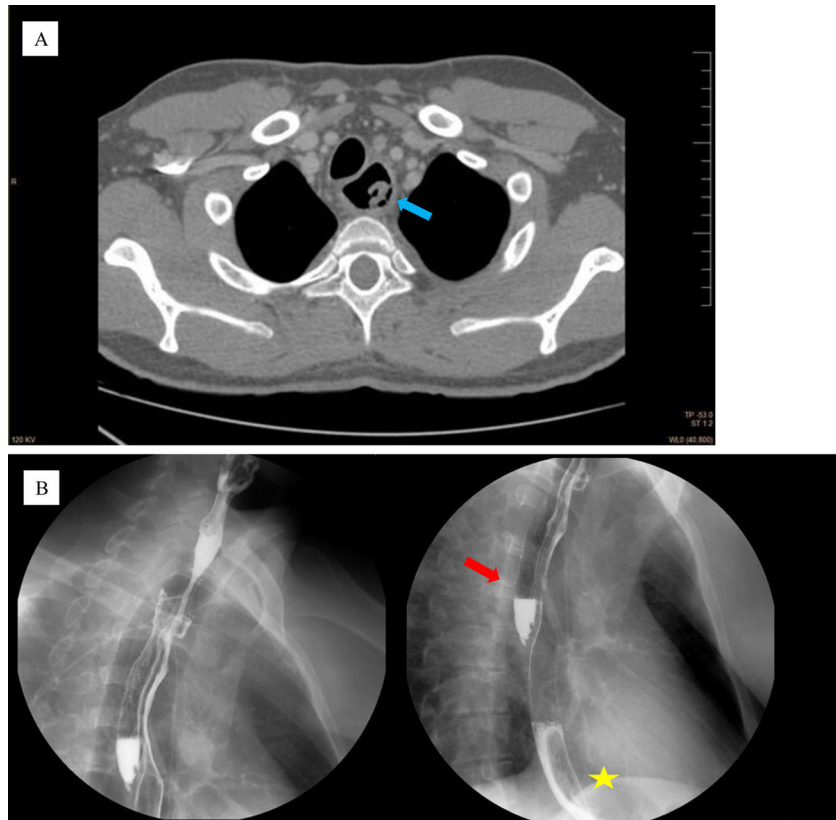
A) Axial CT view: The cervical esophagus is dilated, with a double lumen in its interior that does not communicate with the trachea (blue arrow). B) Esophagogastric transit. Oral contrast medium is shown passing through the esophagus to the esophagogastric junction (yellow star) and into the second esophageal lumen, where it remained static (red arrow).
